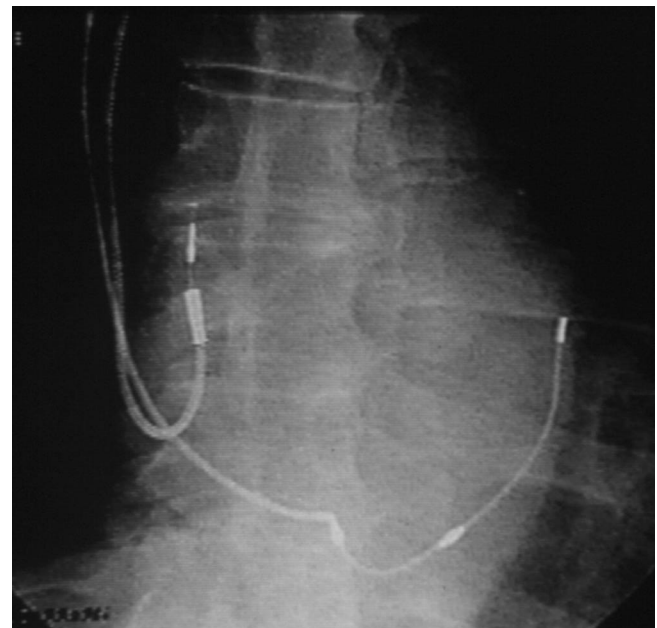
X-ray of the BiA pacing system. A standard J-shaped BP lead located in the RAA and the specially-designed CS lead in the CS. The distant anchoring part of the lead located in the cardiac vein only has only the purpose of ensure stable positioning. Both rings of the lead are designed for LA sensing/pacing in UP (distal ring) and BP (proximal ring as anode) configuration.
